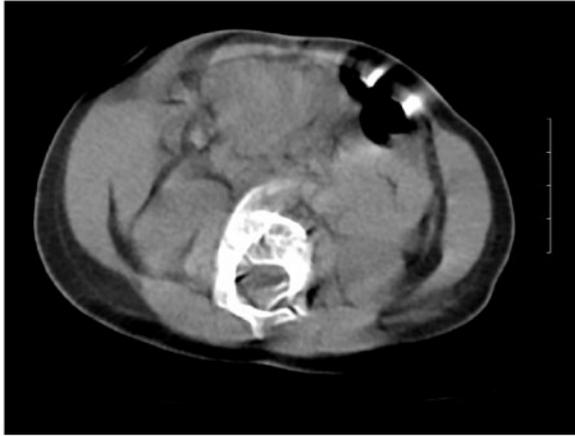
A 7-month-old baby boy with unexplained irritability and suspected abdominal mass. A non-contrast CT scan was interpreted as normal. The CT images were degraded a little by movement artifact. Without contrast, the abdominal study is really uninterpretable, and unnecessary irradiation. Upon transfer to our hospital 5 h later, an abdominal ultrasound study showed an epigastric intussusception mass. Is the CT examination in this case an example of professional malpractice?
